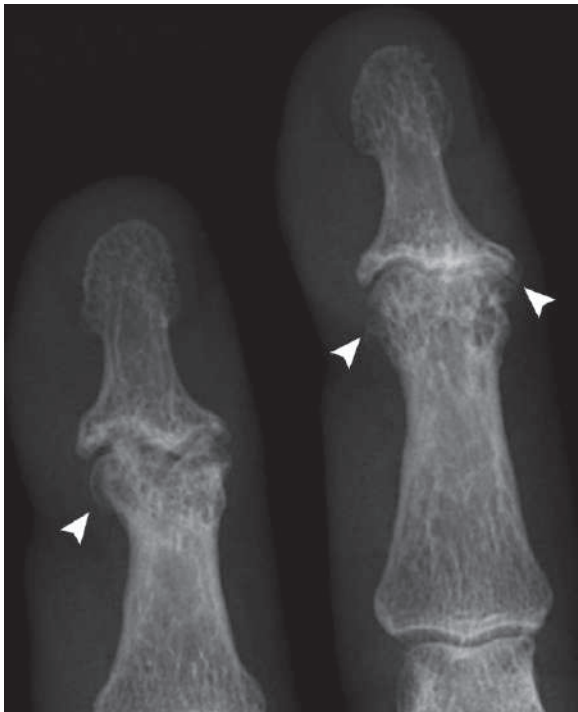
Plain radiograph of the distal fingers in a patient with psoriasis shows narrowing of the DIP joints and marginal new bone formation (*arrowheads*)
